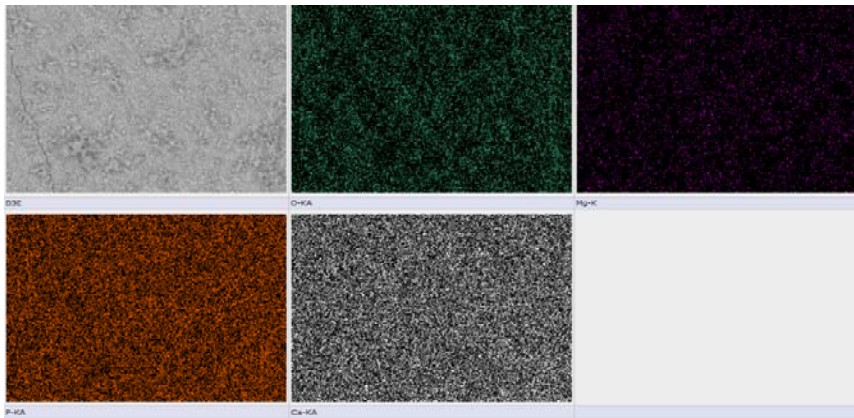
EDS elemental mapping following bio-apatite peening (total particle mass: 10 g). O-KA, Mg-K, P-KA, Ca-KA, and Ti-K indicate the characteristic K α X-ray signals for oxygen, magnesium, phosphorus, calcium, and titanium, respectively.
